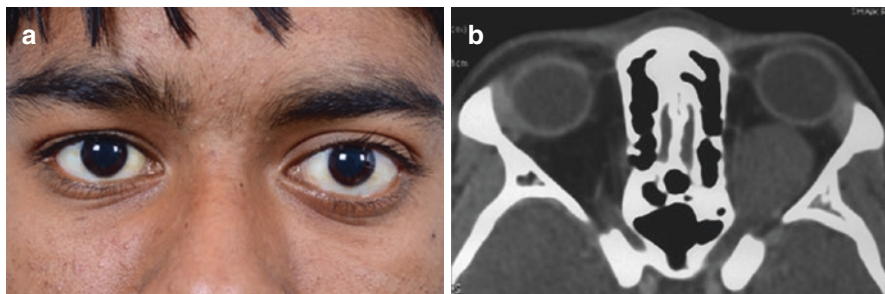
Optic nerve glioma. (a) An 18-year-old male with left axial proptosis. (b) Axial CT orbit shows a homogenous ovoid mass along the course of the optic nerve extending upto the posterior orbit
